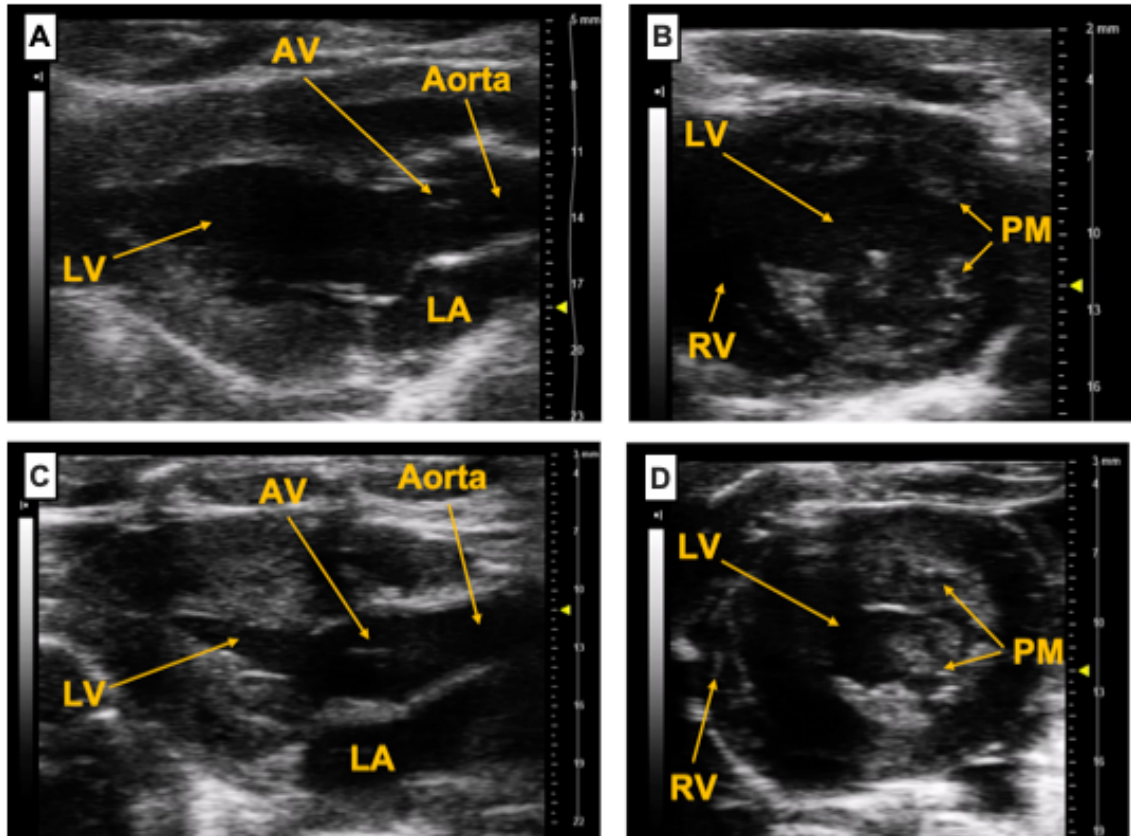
Cardiac ultrasound images demonstrating left ventricular hypertrophy following DOCA-salt treatment
